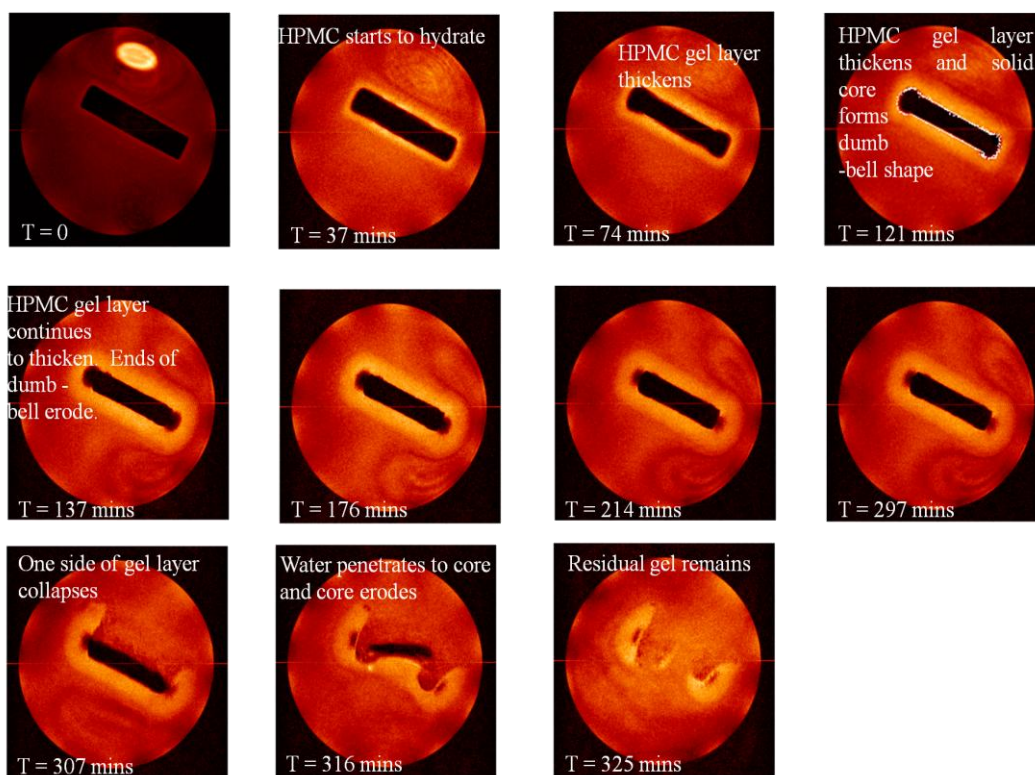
Series of MRI images acquired during 325 minutes dissolution time performed in USP 4 type flow through cell for press coated tablet with expected predicted lag time 3 hours containing HPMC E50LV as an outer barrier layer and theophylline as an active ingredient in the inner core tablet (PLT-3 tablet diameter: 13mm, thickness 2.85mm).
